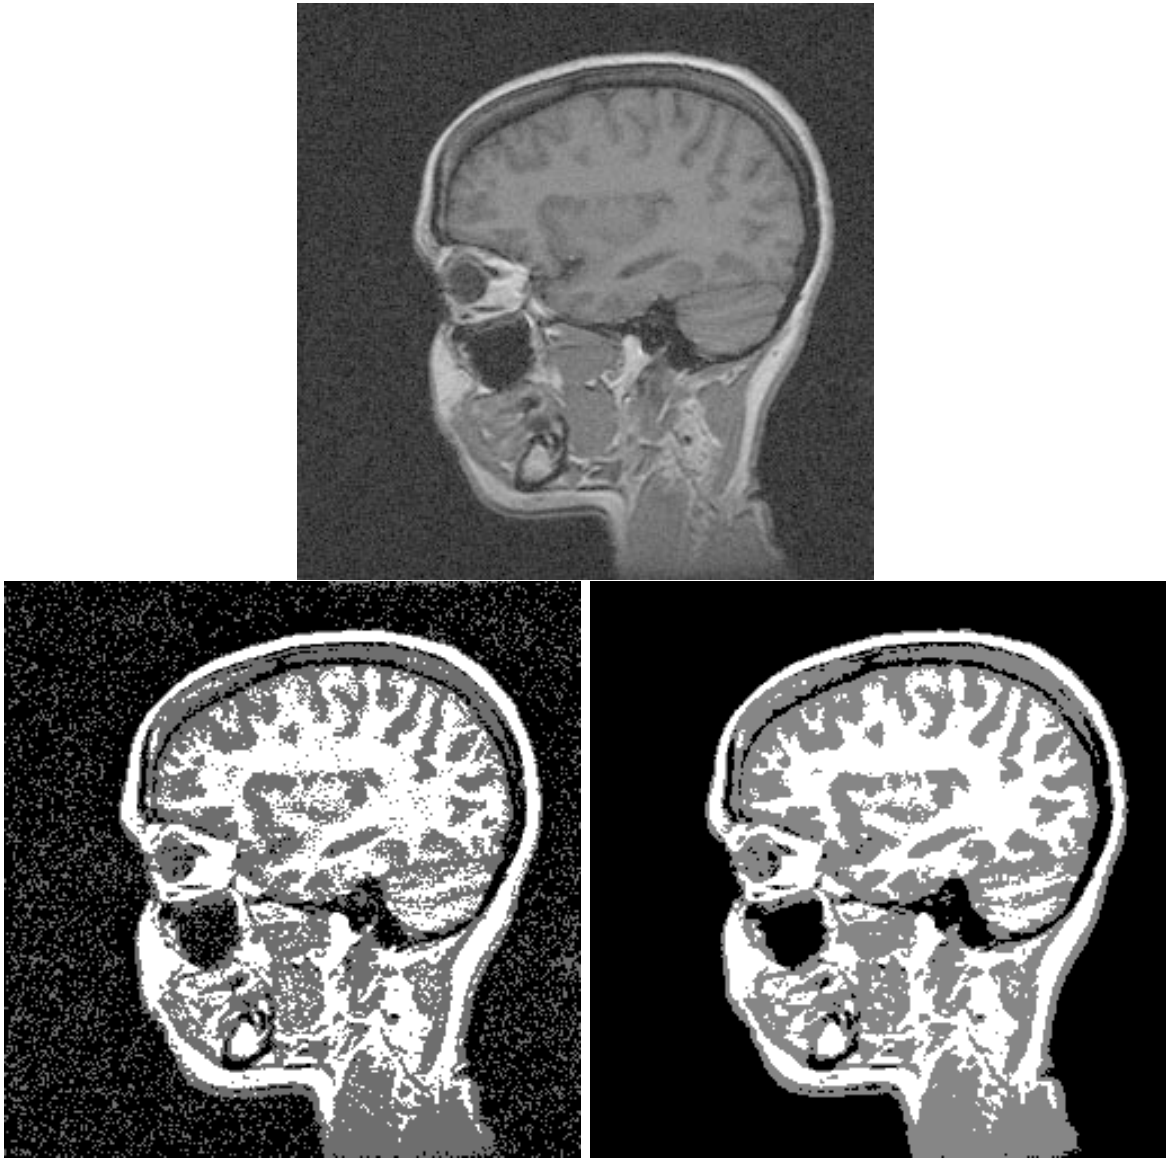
This experiment has been designed to demonstrate the robustness of EM-MF segmentation with respect to thermal noise in MRI. The top image was prepared by adding a substantial amount of Gaussian i.i.d. noise to a gradient echo MRI scan. The bottom left image shows the result of standard EM-segmentation (3d) into three classes: white matter, gray matter, and background. The bottom right image shows the EM-MF segmentation (3d). In both segmented images, white matter is shown in white, gray matter is shown in gray, and the background/air is shown in black. Note how the EM-MF approach has effectively suppressed the effects of this noise in the segmentation while preserving structural details.
